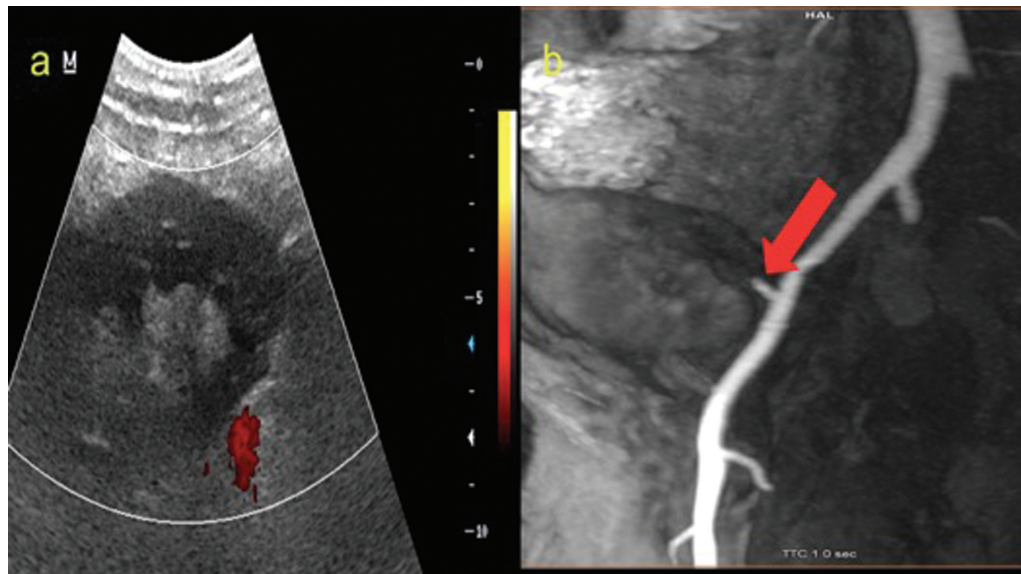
Power doppler image (a) of the transplanted kidney shows the absence of intraparenchymal vascularity in the entire kidney, s/o global infarction. (b) Contrast-enhanced MR angiography shows complete occlusion of the renal artery (red arrow) distal to its anastomosis. MR, magnetic resonance.
